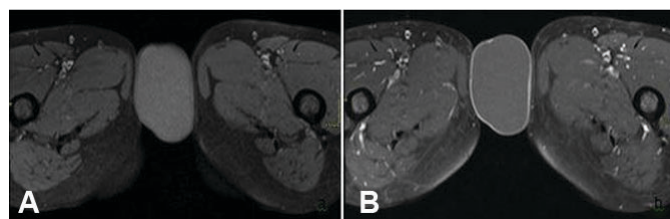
On (A) T1 FAT SAT weighted axial image, the lesion shows hyper-intense signals as compared to adjacent muscles, while on (B) T1-weighted post-contrast images, the lesion demonstrates a thin rim of peripheral enhancement.
